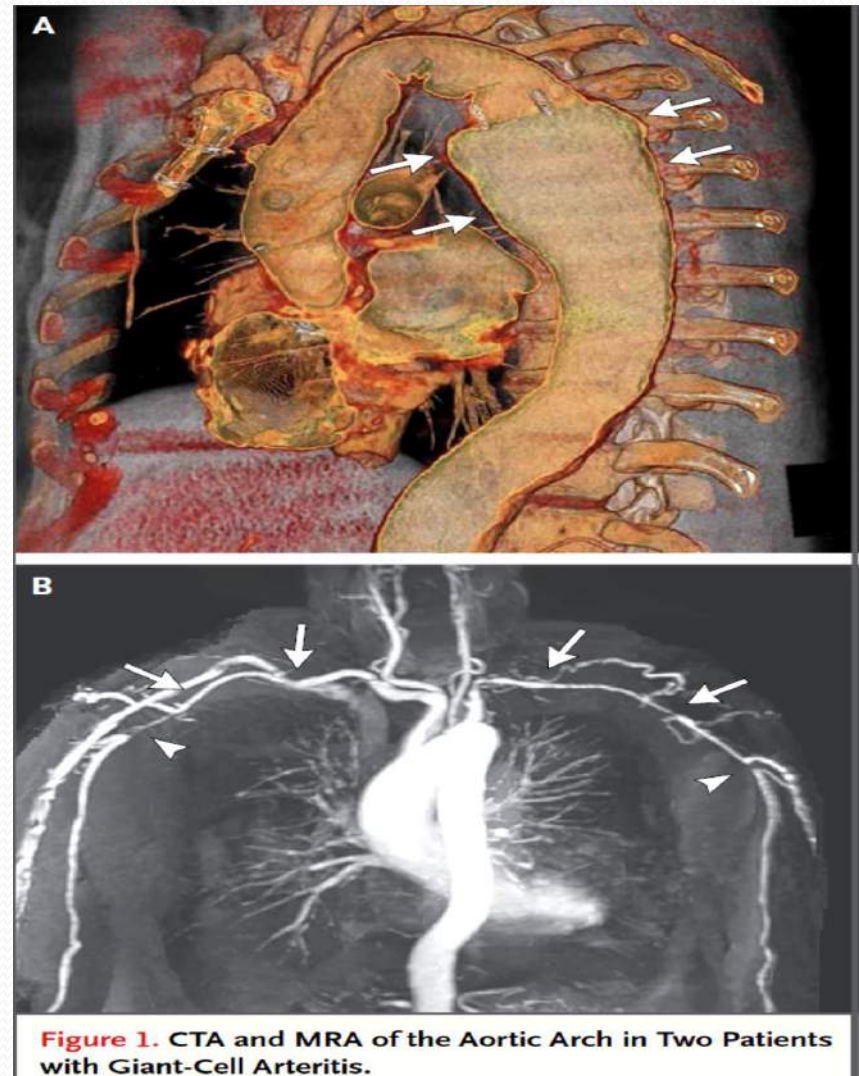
CTA and MRA of the Aortic Arch in Two Patients with Giant-Cell Arteritis.
